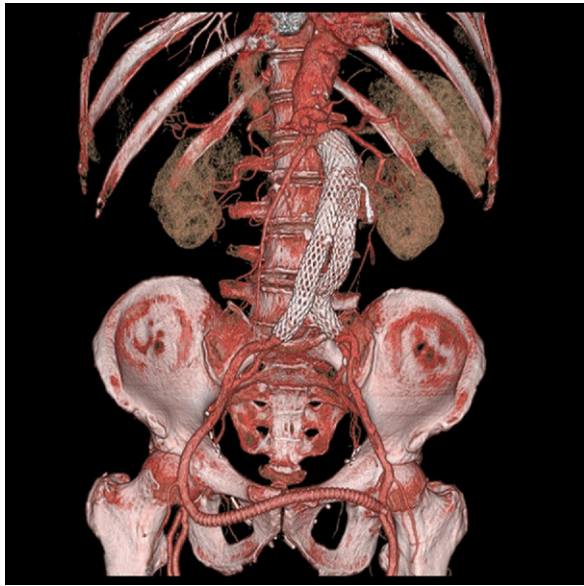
Volume rendered computed tomography angiography depicting the location of the endografts as well as the femoral-femoral bypass.
